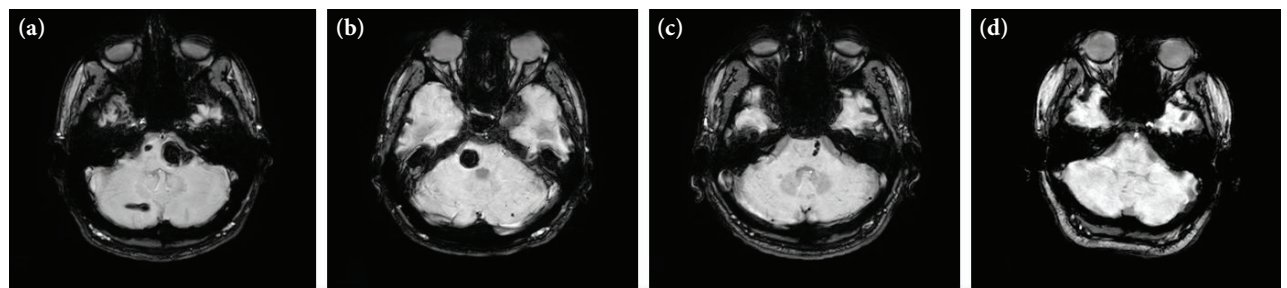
Axial brainstem imaging. (a) Index patient's SWI sequence MRI. (b) Patient's brother's SWI sequence MRI. (c) Patient's father's SWI sequence MRI. (d) Patient's mother's normal MRI.
